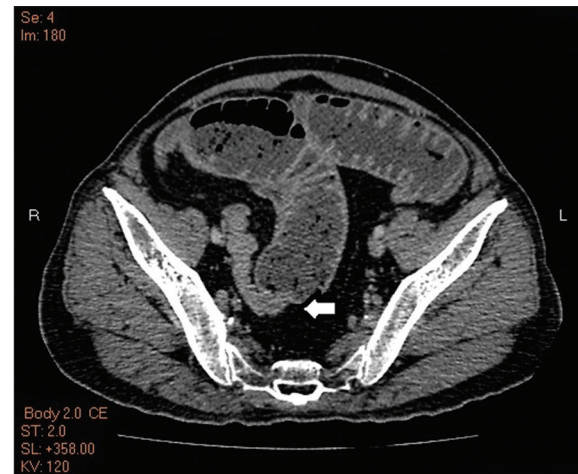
Abdominal computed tomography showing marked dilatation of proximal small bowel loops with a collapsed distal ileum and colon indicating small bowel obstruction; no gross organic lesions were found around the transitional zone (white arrow)
